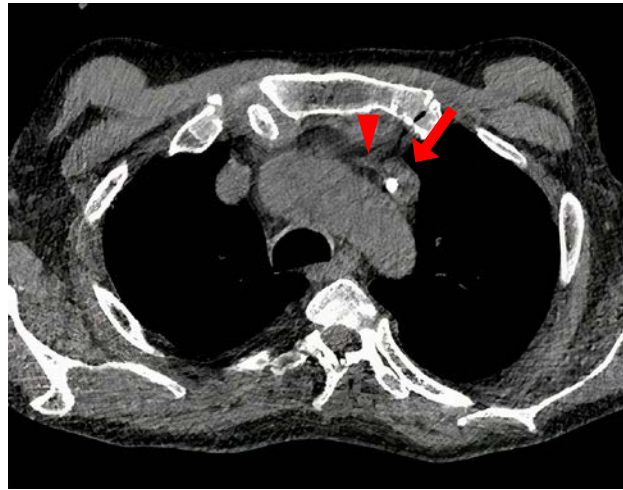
Chest CT demonstrating a persistent left superior vena cava with the catheter within (arrow) and a hypoplastic left brachiocephalic vein (arrowhead).
